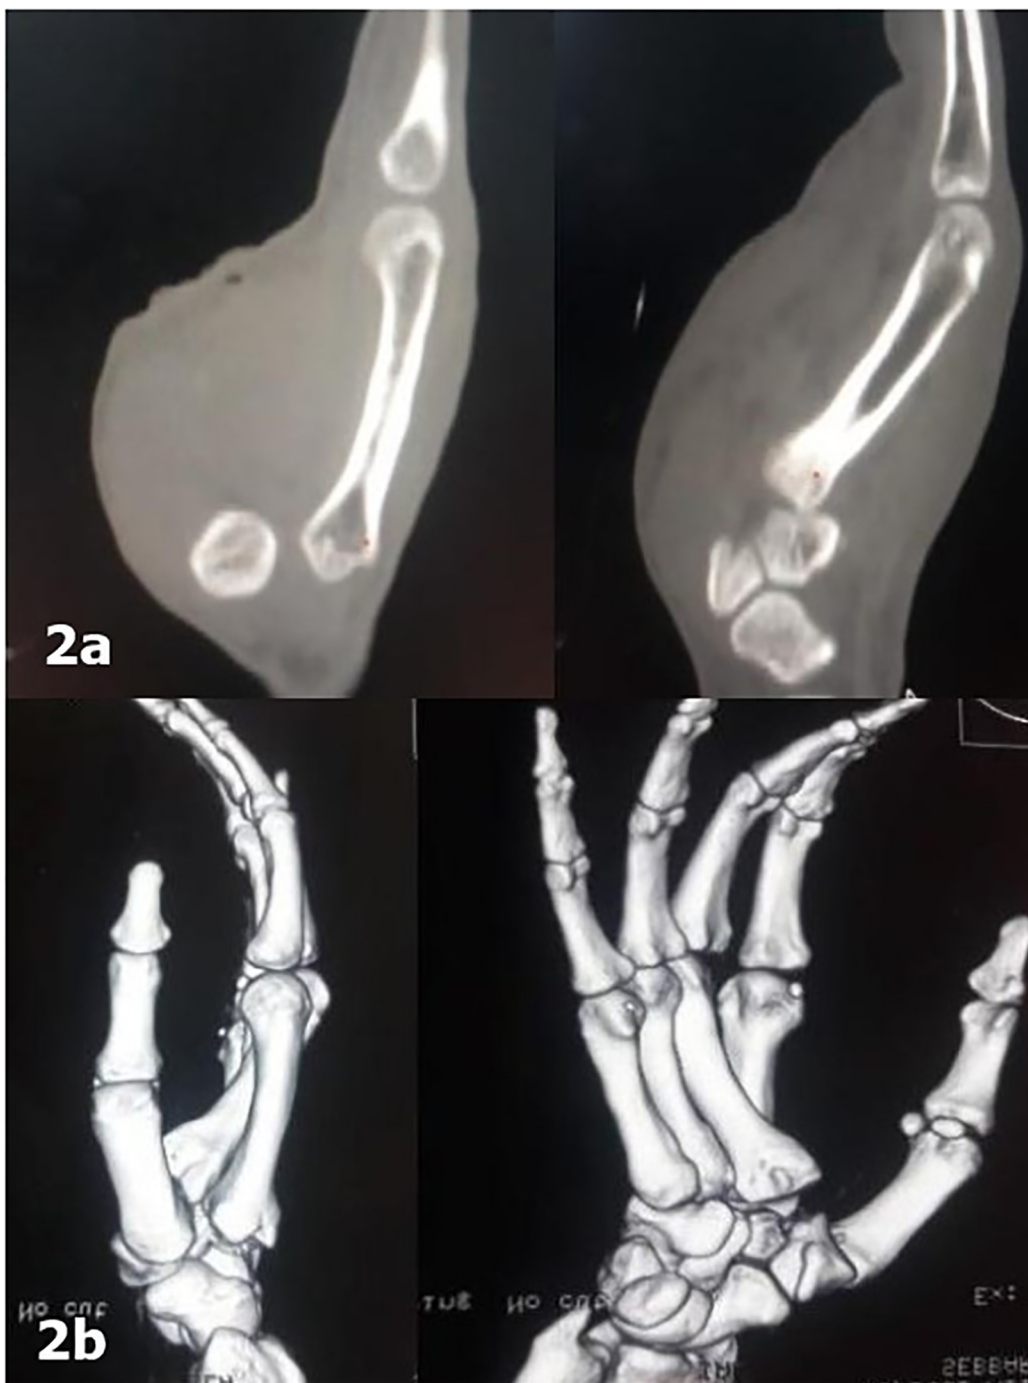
Sagittal (a) and 3D CT-scan (b) showing divergent dislocation of 2nd and 3rd CMC joint.
